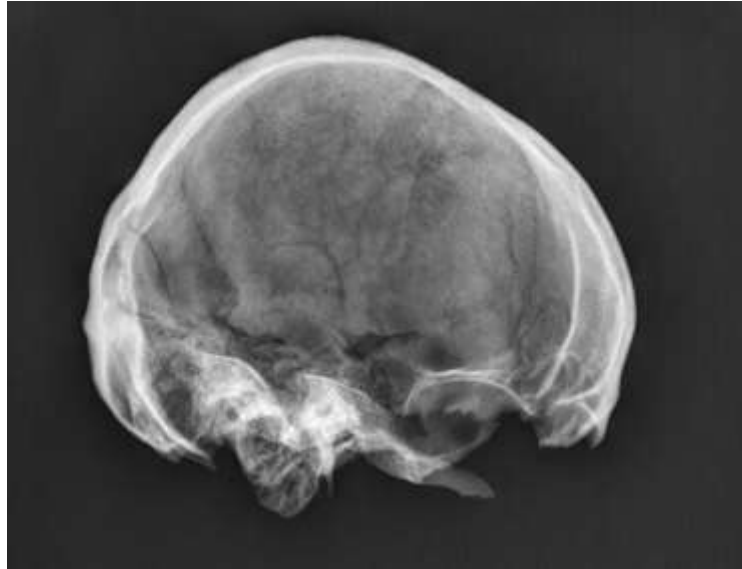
X-ray image of the skull
